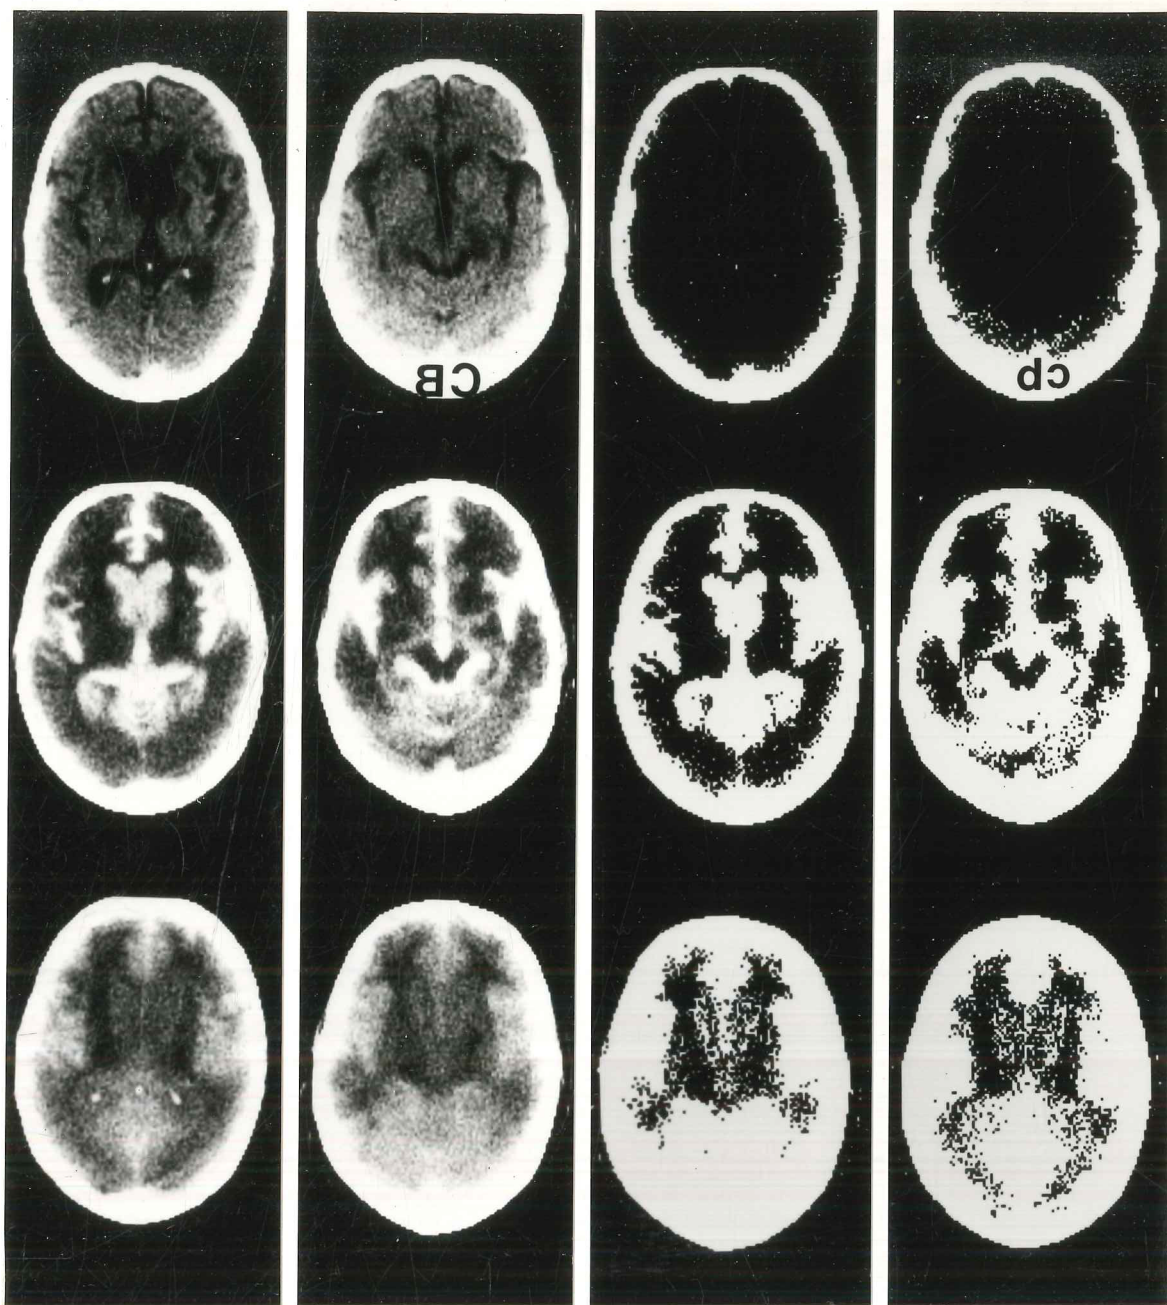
CT scans in patient 13 before and at 6 (middle) and 24 (bottom) hours following lumbar myelography. Gross atrophy is demonstrated and following intrathecal CM dense CM is noted at 6 hours in the basal cisterns, sylvian fissures and ventricular system. At 24 hours, dilute CM obscures the definition of the lateral ventricles and extensive CM penetration into the grey matter persists. Although less prominent, some penetration across the ependyma from the ventricles into the white matter has also occurred.
